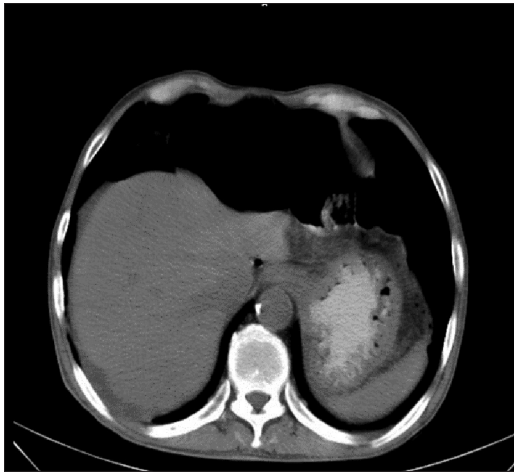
The abdominal computed tomography revealed a gastric distension as a result of the pyloric stenosis, accompanied by the evidence of some gas-filled cyst in the wall of the stomach
